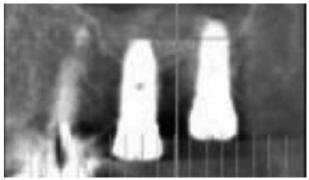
G. Three days after surgery, post-operation CT scan and panorama was taken. In the Panoramic view of CT scan, adequate amount of bone was filled around fixtures.
